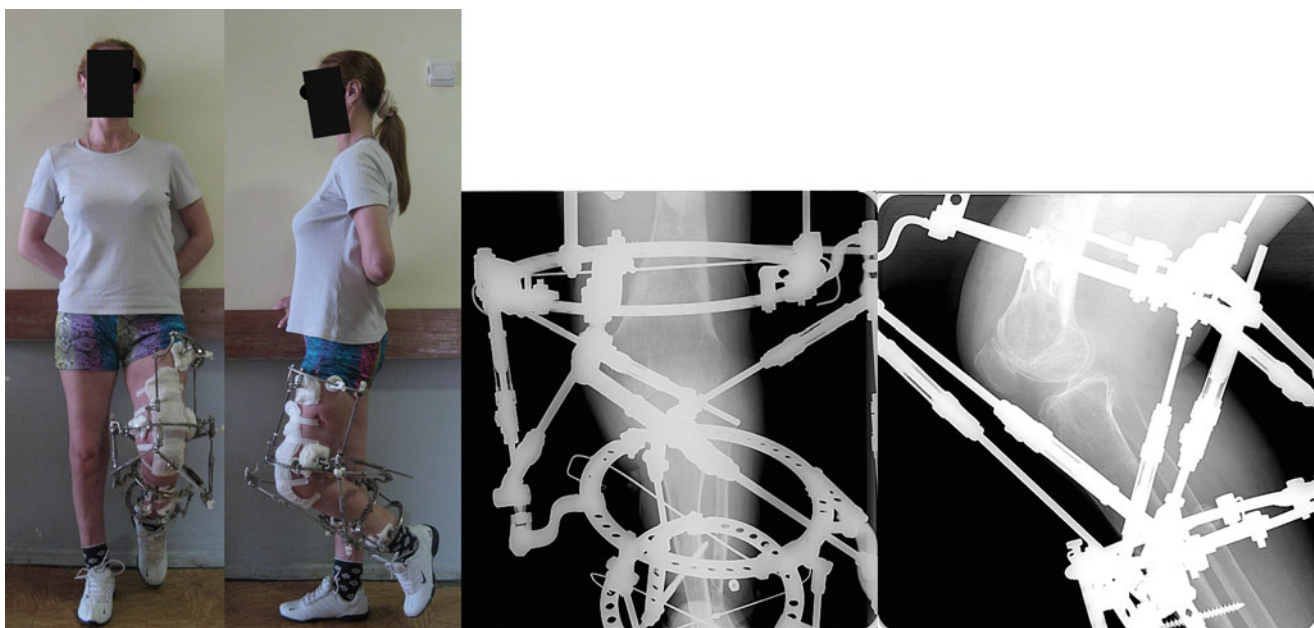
Photos and radiographs during treatment. ROM is 45/0/0. Note the normal congruency of the knee joint
